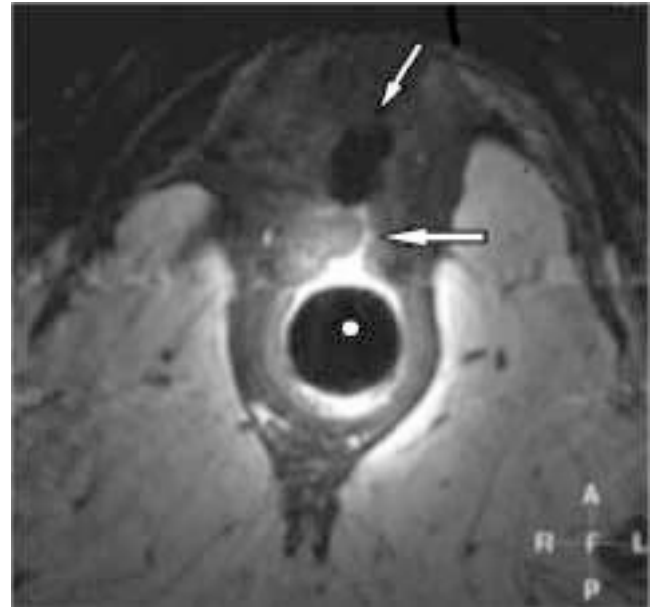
Rectovaginal fistula as seen on MRI.
